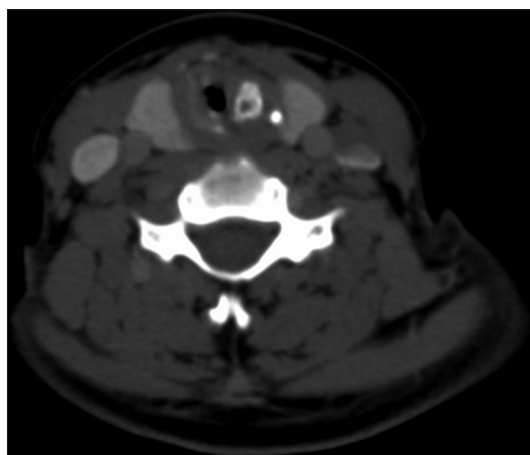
CT scan of the neck. Cross sectional view, show subglottic stenosis with asymmetric arytenoid calcification
